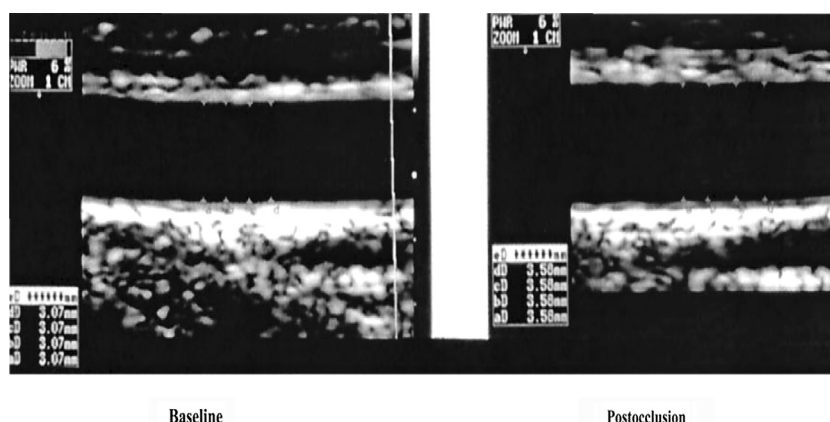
Ultrasound images of a brachial artery under baseline and after cuff-occlusion conditions.
